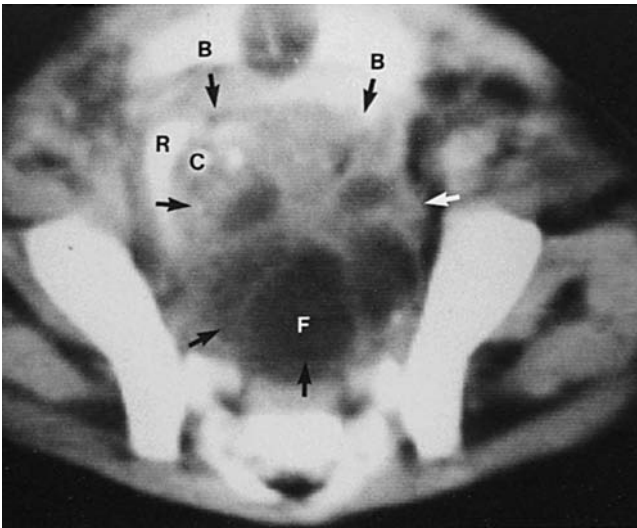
Presacral teratoma. Computed tomographic section of pelvis with contrast medium enhancement shows a large cystic mass (arrows). The mass contains both fat and calcification, and displaces the rectum anteriorly and laterally, and the bladder anteriorly. B, bladder with Foley catheter; C, calcification; F, fat; R, rectum.
